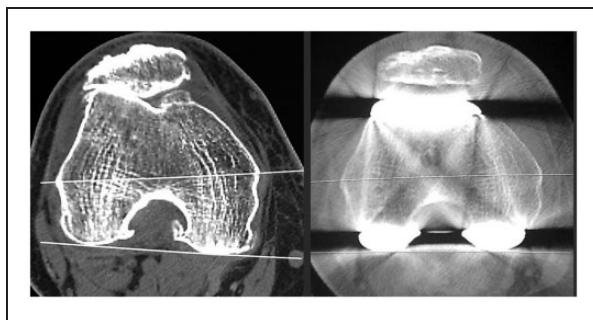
Preoperative and postoperative CT femoral rotation measurements.
